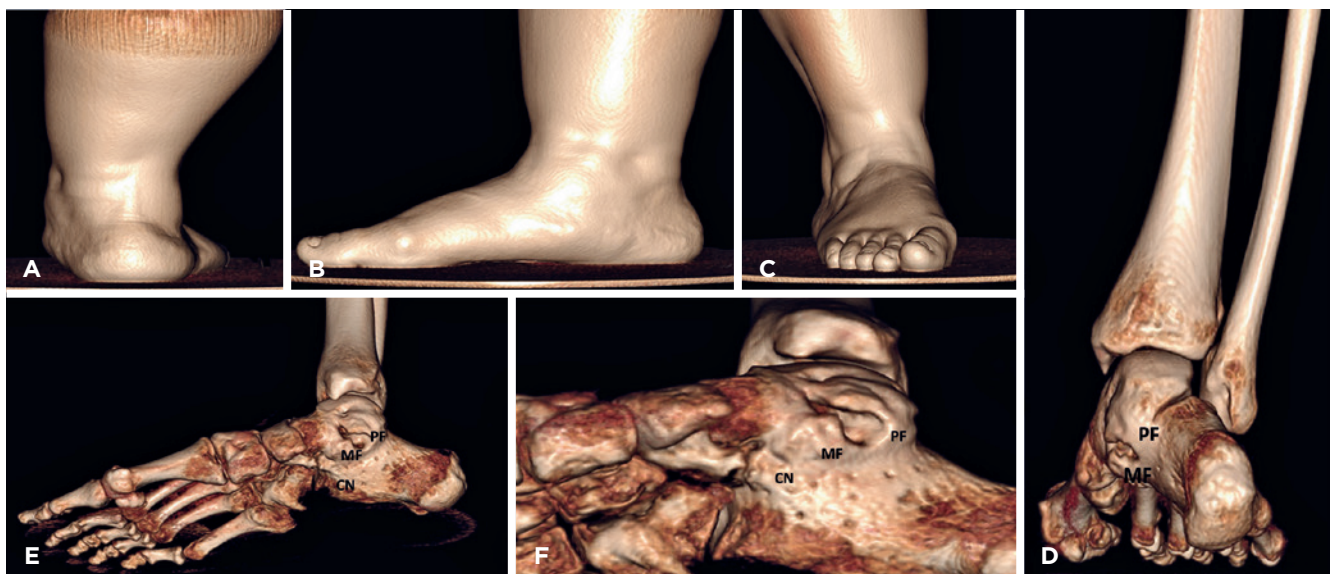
(A) Posterior, (B) medial, and (C) anterior weightbearing CT 3D reconstructions of patient's foot and ankle surface anatomy, demonstrating severe hindfoot valgus and flatfoot. (D, E, and F) Weightbearing CT 3D bony reconstruction showing extensive SJ middle (MF) and posterior facet (PF) coalitions, as well as the residual plantar calcaneonavicular coalition (CN).
